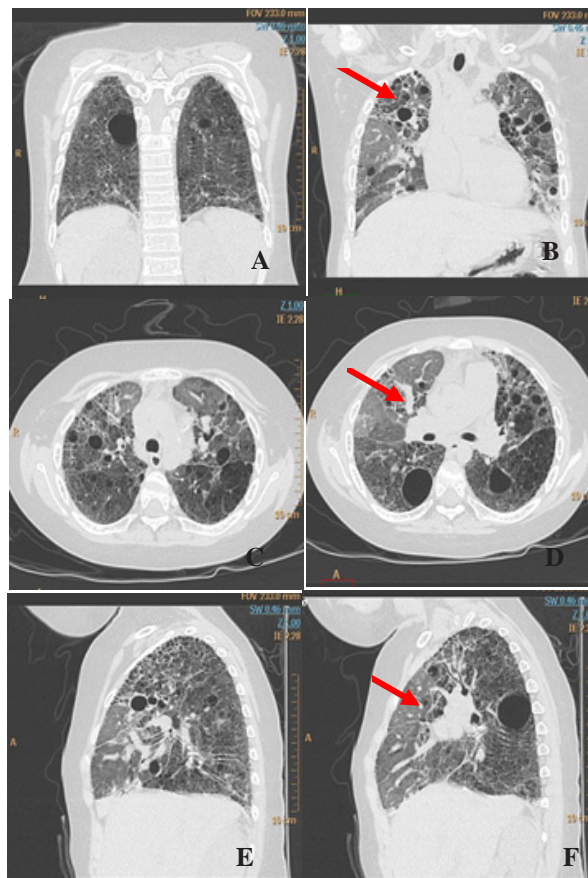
Chest CT scan done of an 8 year old female with interstitial lung disease on admission. There are reticular and linear pattern due to fibrosis. (A,B) with note of 1-2 cm air containing cysts (A, D, F). There are ground glass pattern seen in the middle lobes (D,F)
